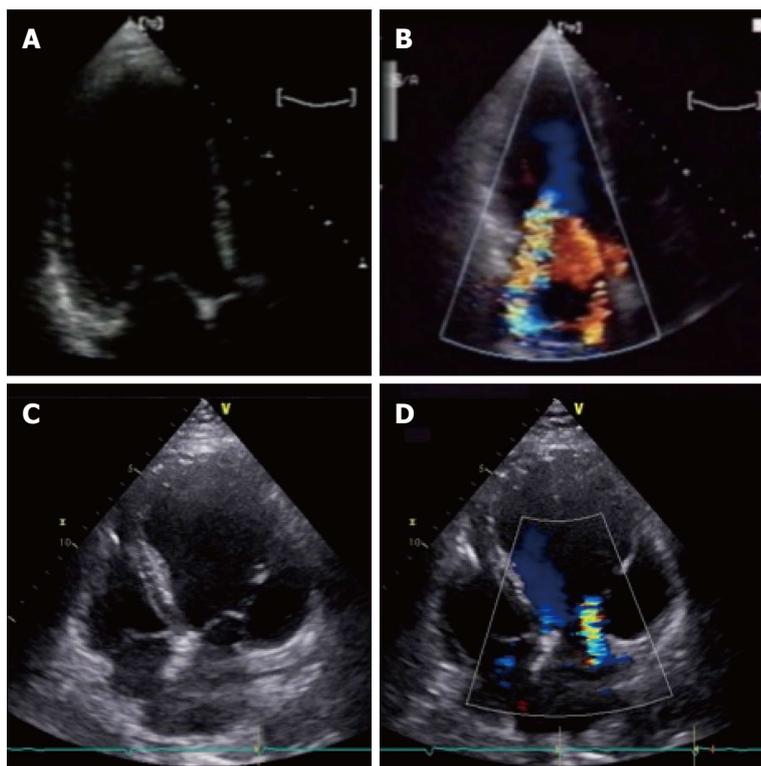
Asymmetric and symmetric tethering pattern. A, B: Asymmetric tethering pattern. Typical “hockey stick” or “bent knee” configuration. MV coaptation point is moved posteriorly and the anterior leaflet coapts creating a “pseudo-prolapse” appearance with a large regurgitant jet oriented along the posterior wall of the left atrium; C: Symmetric tethering pattern. Both leaflets are apically dislocated and coapt at the same level into the ventricle; D: Color-Doppler shows large central jet.
